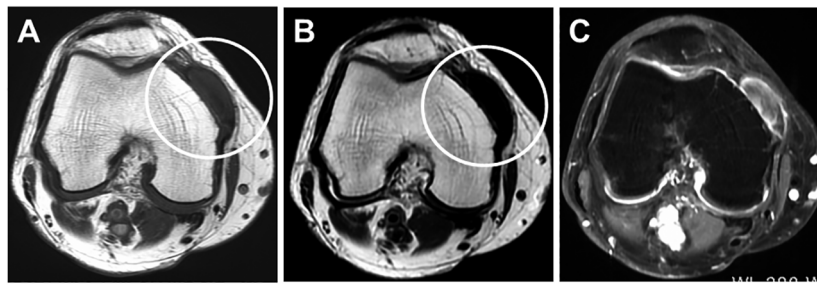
Axial magnetic resonance images of desmoplastic fibroblastoma in the right knee. The mass (circle) reveals low signal intensity on both T1-weighted (A) and T2-weighted (B) sequences. Contrast-enhanced fat-suppressed T1-weighted sequence (C) demonstrates mild heterogeneous internal enhancement with rim enhancement.
